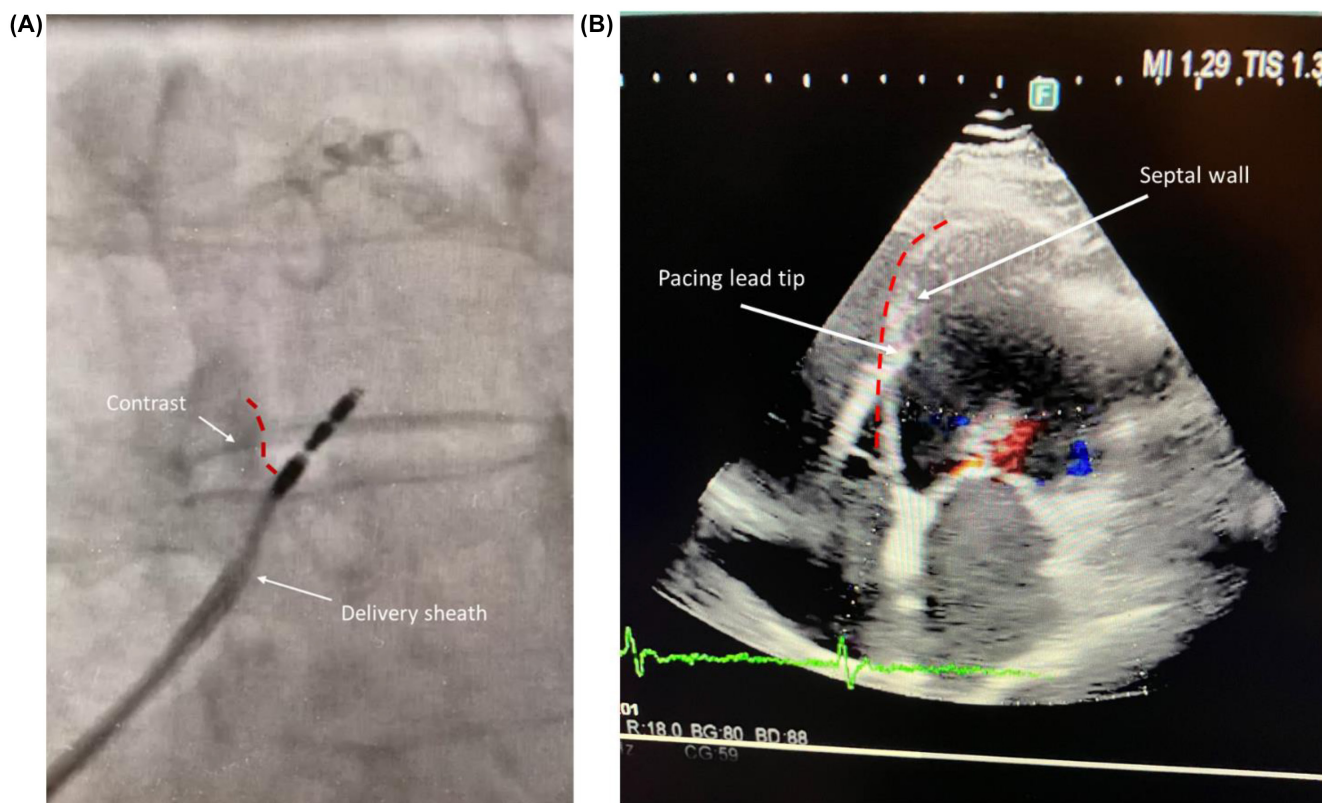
(A) X-ray image in the left anterior oblique 30° projection view, contrast medium is used to highlight the stylet-driven lead penetration into the septum. (B) Echocardiogram showing lead penetration in LBB area. The septal wall is indicated by a red dashed curve.
